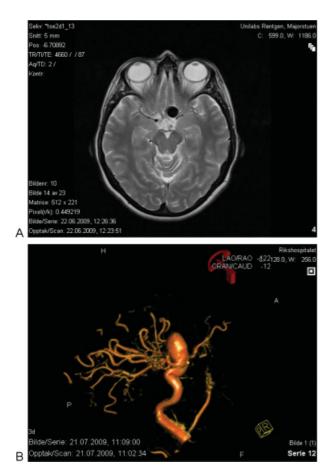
Magnetic resonance imaging (MRI) of a 56-year-old righthanded woman who presented with a 4-month history of retro-orbital headache and progressive visual loss demonstrating a left-sided ophthalmic artery aneurysm $20 \times 12 \times 13$ mm in diameter. (A) Axial T2-weighted MRI demonstrating the relationship to the left optic nerve. (B) Three-dimensional digital subtraction angiography demonstrating the aneurysm sac.
